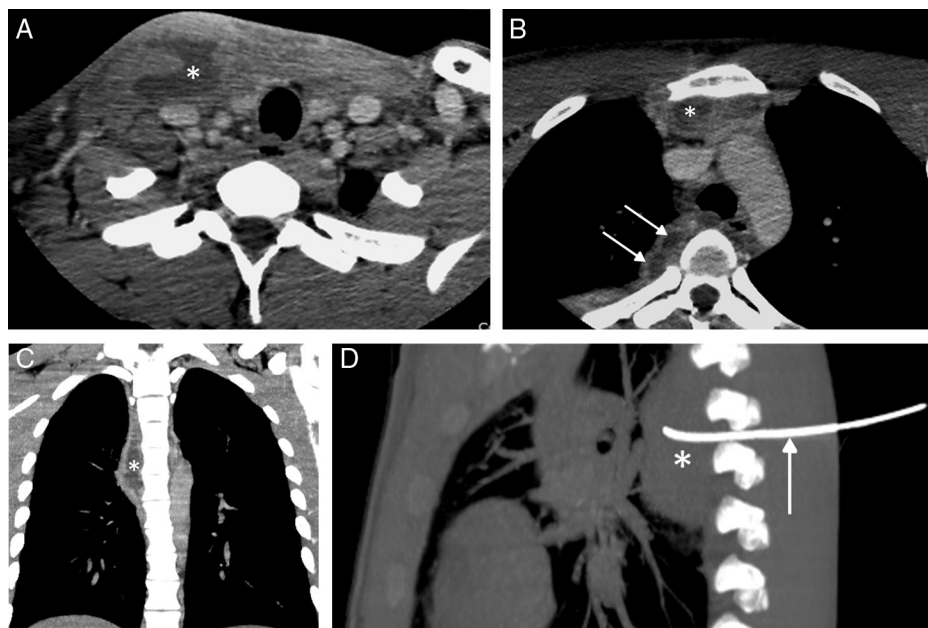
(A) Axial computed tomography (CT) image of the neck showing a collection in the right sternocleidomastoid muscle. (B) Axial CT image of upper chest showing a collection in the anterior mediastinum (asterisk), and another multiseptated collection in the posterior mediastinum (arrows). (C) Coronal reconstruction of chest CT with a better view of the posterior mediastinum collection extending downwards from the head. (D) Sagittal reconstruction of chest CT showing "pigtail" drainage tube (arrow) placed in the posterior mediastinal collection.
